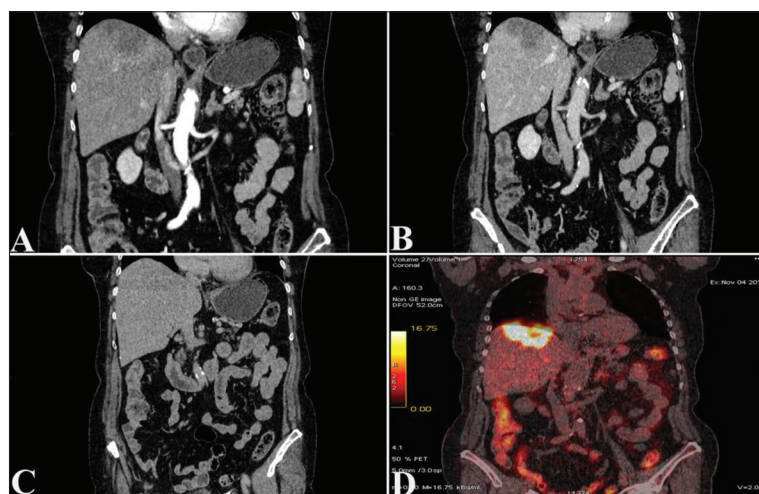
Contrast-enhanced abdominal computed tomography and F-18 FDG positron emission tomography scan in the coronal plane: (A) arterial phase showing a hypodense, slightly lobulated, lesion in segment VIII with peripheral rim-enhancement; (B) hypodense lesion during the portal phase; (C) same attenuation as liver parenchyma during the delayed phase; (D) hypermetabolic mass lesion in the liver
